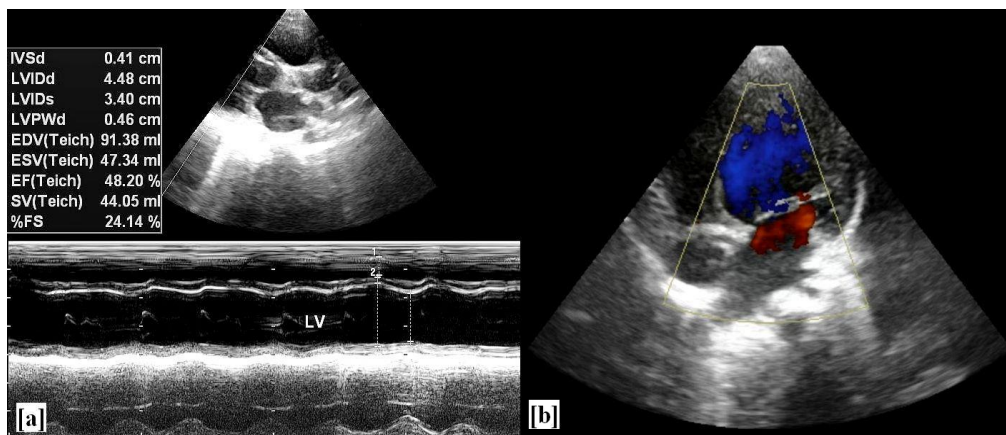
(a) Parasternal long axis view M-mode study showing dilated LV with reduced EF (b) Apical 5-chamber view with color flow doppler showing dilatation of all cardiac chambers.
